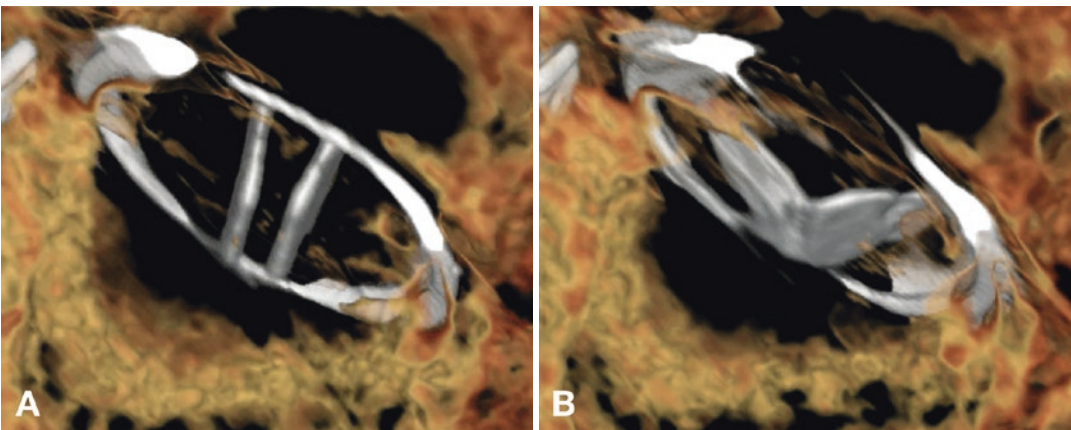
Retrospectively gated CT from a patient with severe aortic vascular regurgitation following valve replacement surgery. A mechanical aortic valve opens
